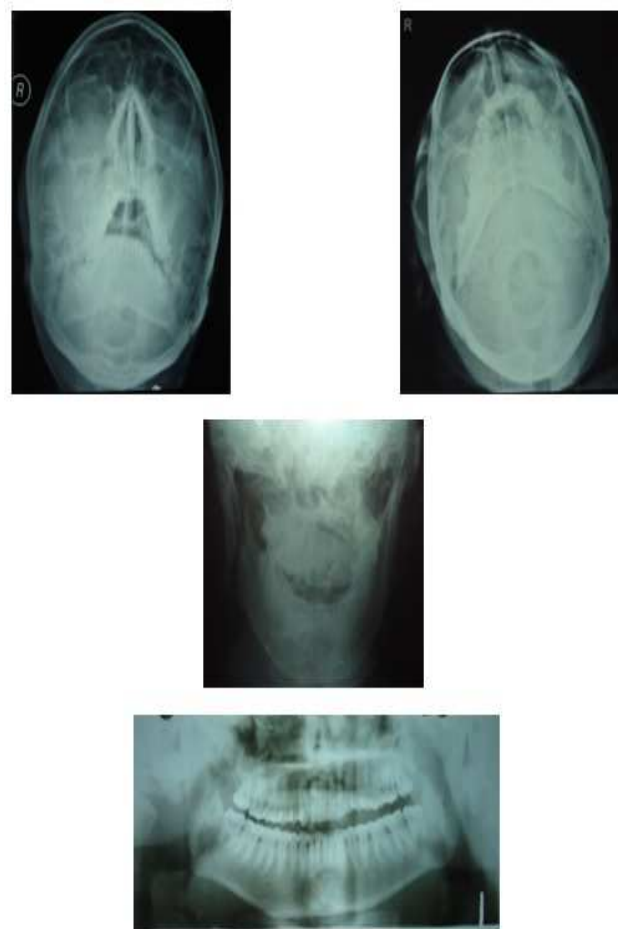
Conventional radiographs (Waters view, SMV view, PA view mandible and OPG) of patient 1 with fractures Lefort II, right zygomatic maxillary complex, and right ramus of mandible
